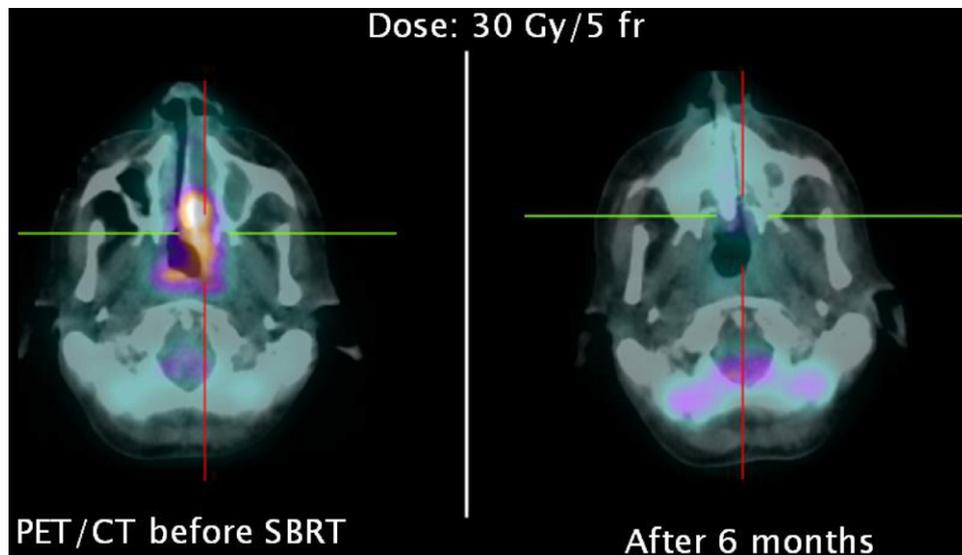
Case 1: Direct comparison of PET/CT axial images before and 6 months after the SBRT re-treatment (30 Gy in 5 fractions), showing a complete response of nasopharynx recurrence.
